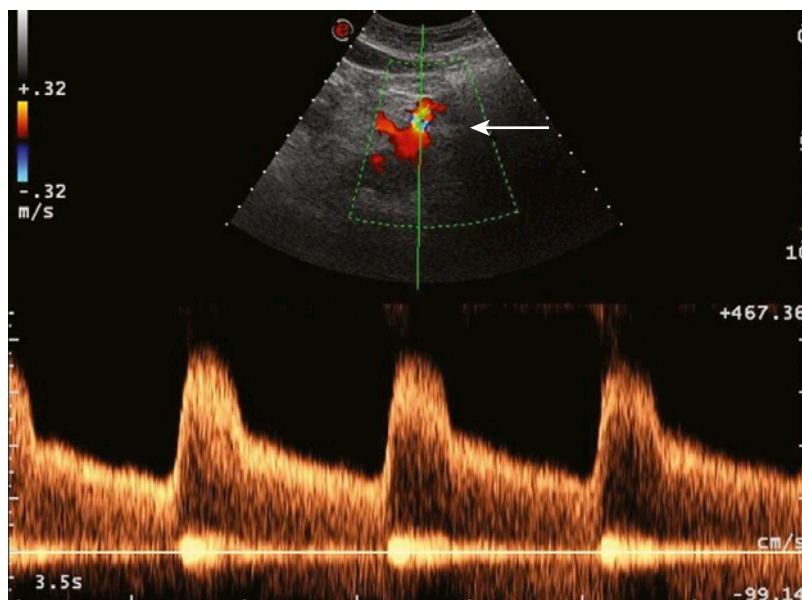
Stenosis of the celiac trunk (*arrow*) is seen as a mixture of colors (i.e., aliasing) in a patient with Churg-Strauss syndrome. The pulsed-wave Doppler curves show that the maximum systolic velocity is increased (450 cm/s).
